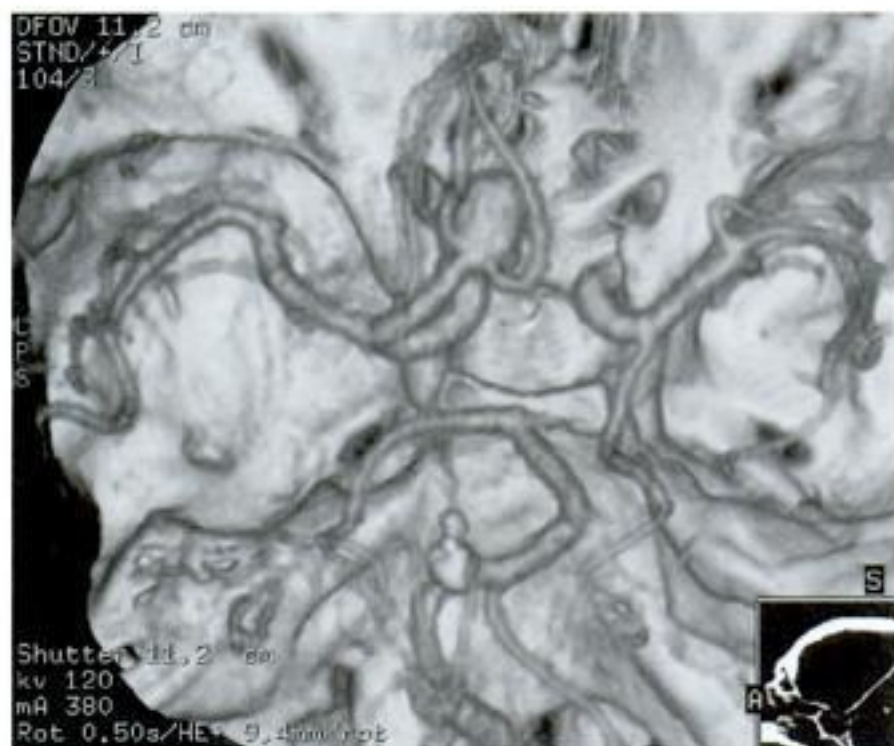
Three-dimensional reconstruction of a CT-angiogram (superior view). This broad-necked, anterior communicating artery aneurysm was found during the workup for headaches. It is fed by a dominant left A1 segment and there is a hypoplastic right A1 segment.
